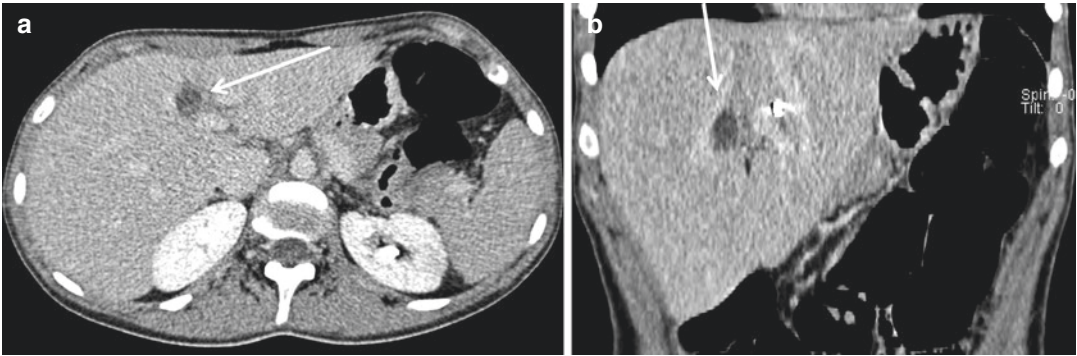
(a) Axial CT scan and (b) coronal reconstruction show a small biloma (less than 3 cm) caused by lacerations affecting bile ducts (arrows)
